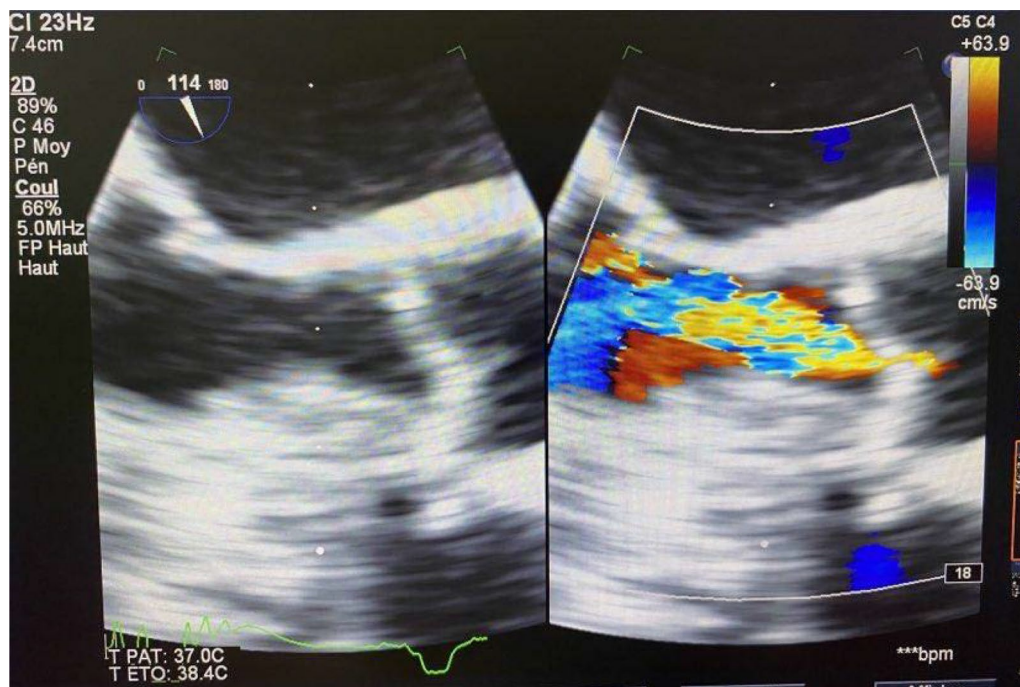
Two-dimensional (2D) transesophageal echocardiography showing grade 2 aortic valve regurgitation
